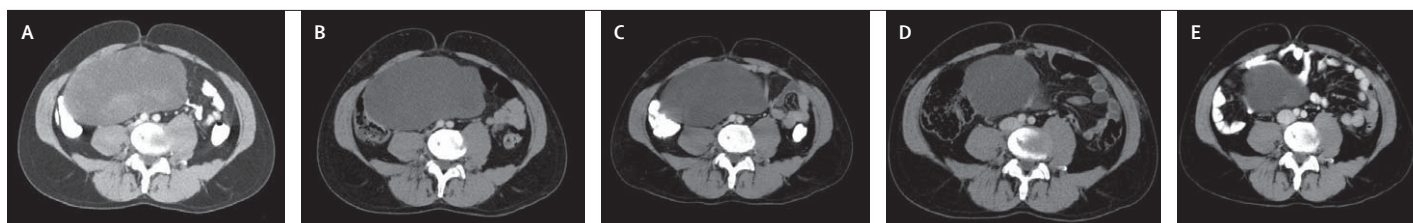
Sequential CT scans of abdominal tumour displaying a decrease in tumour density followed by a decrease in tumour dimensions in patient 21
